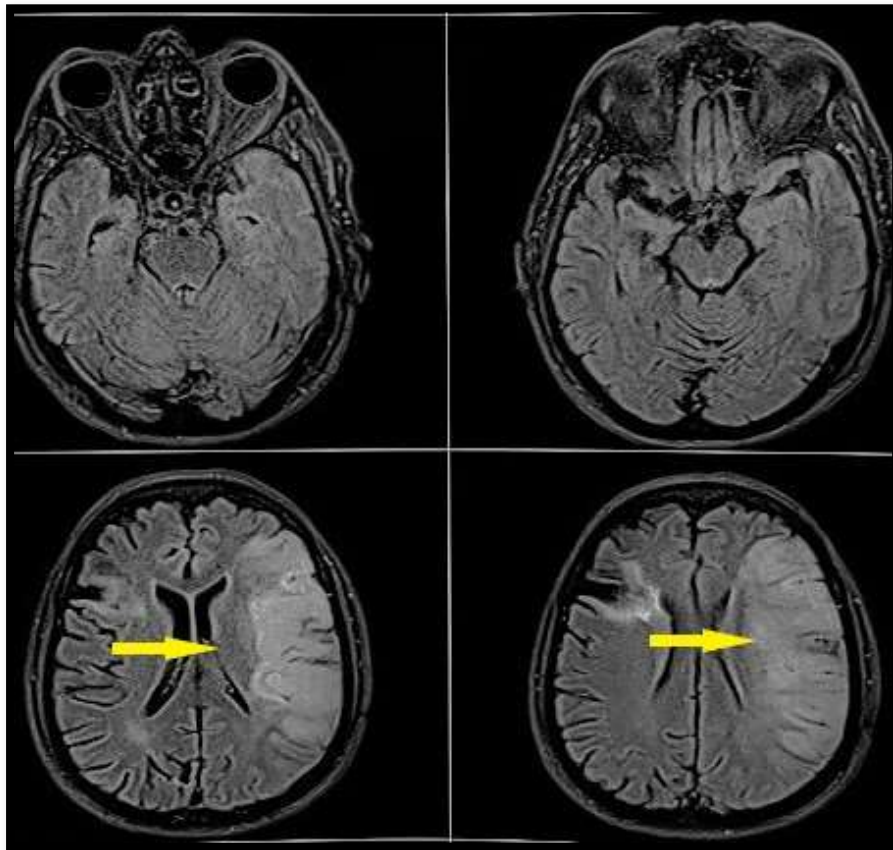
Infraction in Left MCA territory (MRI)
